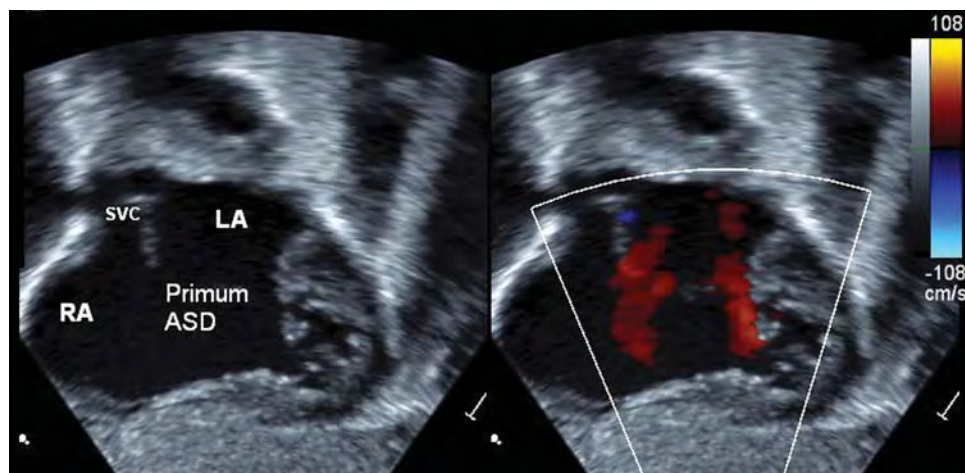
Subxiphoid view in color Doppler mode of a large ostium primum atrial septal defect in a patient with incomplete common atrioventricular canal. Left to right flow across the defect can be seen (red flow seen on right side of panel). ASD, atrial septal defect; LA, left atrium; RA, right atrium; SVC, superior vena cava.
